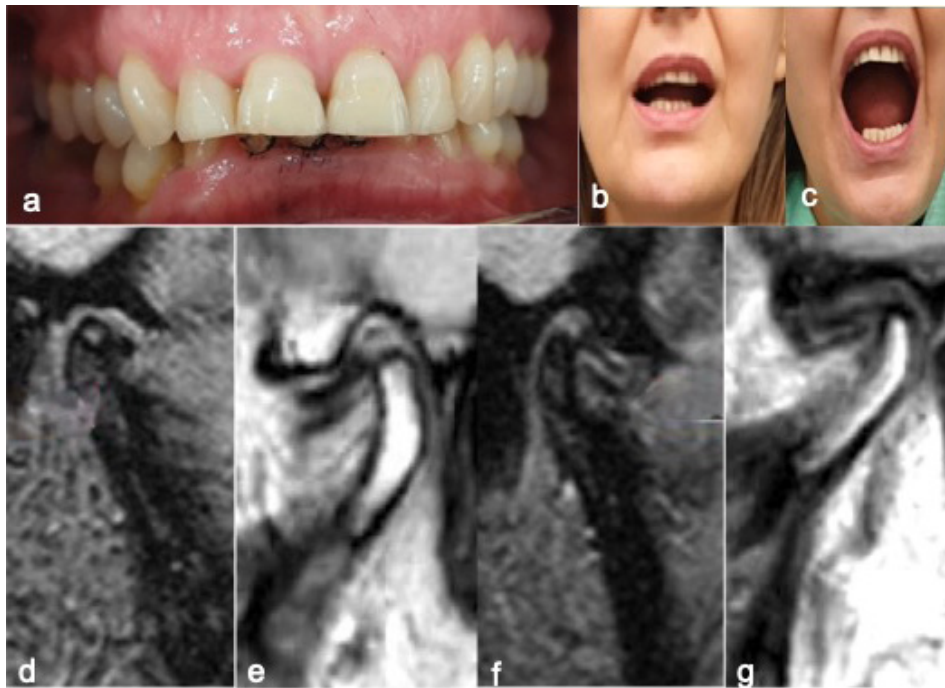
Case three. (a): The patient presented an increased overjet and overbite; (b): The mandibular pre-treatment opening is limited, there was a mandible deflection, the opening pathway is shifted to one side and becomes greater with opening; (c): The objectives of the treatments were to eliminate the pain and sound, the mandibular opening is normal and without deviations; (d): Pre-treatment, in the left one the disc appeared less dislocated; (f): In the third that was the more complex case for the management, the MRI were obtained also after the jaw manipulation and the images confirmed at right TMJ presence of anteriorized disc position in maximum intercuspitation; (e, g): After 2 years MRI image shows a retrodiscal tissue modification, we hypothesized due the fibrosis caused by retrodiscal tissue functionalization.
